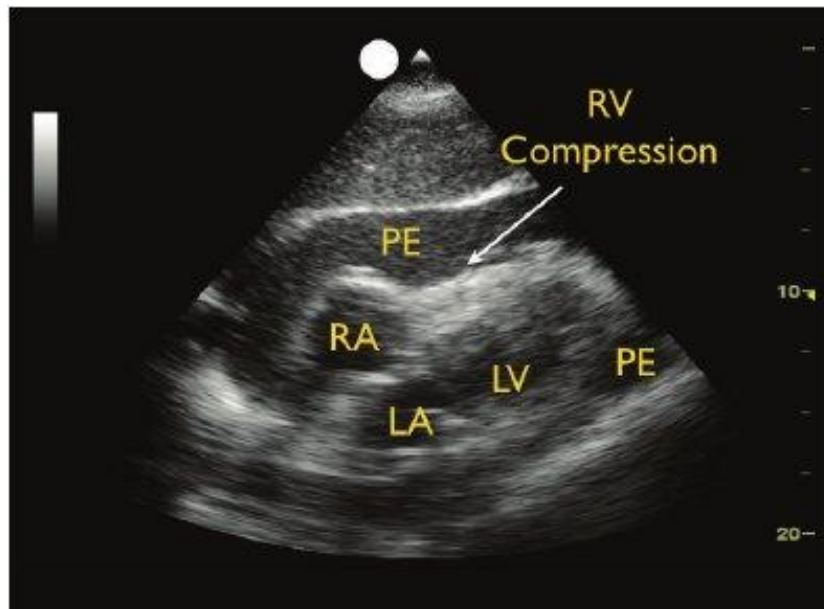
Pericardial effusion, parasternal long axis view. RV: right ventricle, LV: left ventricle, LA: left atrium [19]
